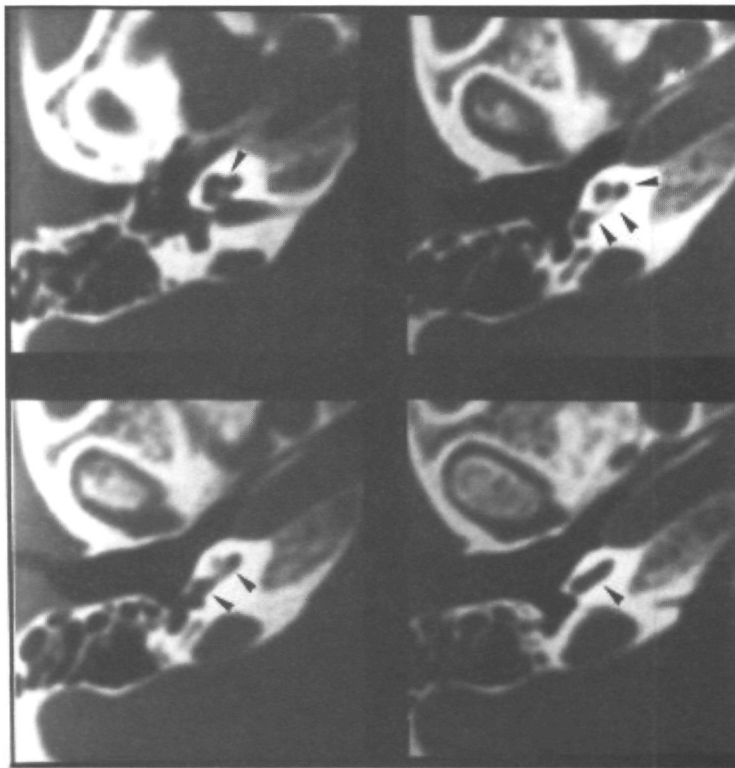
Same patient. Multiplanar reconstruction parallel to the left basal turn, reconstructed from axial FISP 3D data set. Although MRI does not show specific alterations indicating otosclerosis, focal signal loss of the basal cochlear turn is demonstrated (arrows).
